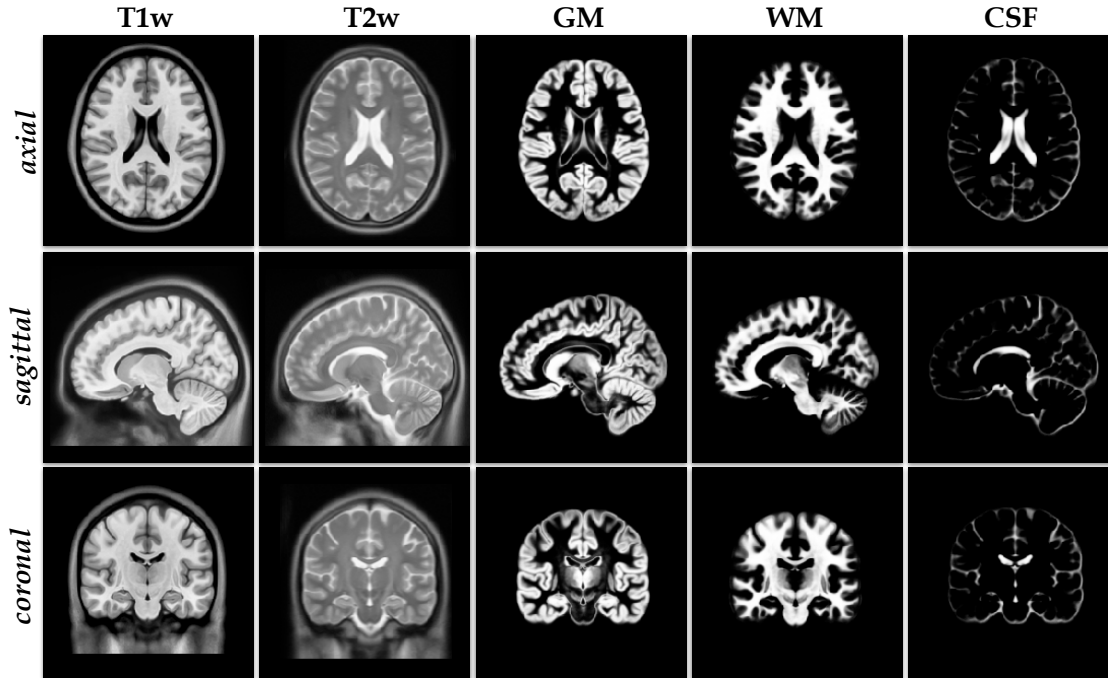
The T1w and T2w MRI atlas of the healthy adult human brain together with tissue probability maps provided by [50]. A subject-specific structures like face are usually blurred while structures similar across subjects, like brain tissues, are more clearly pronounced.
